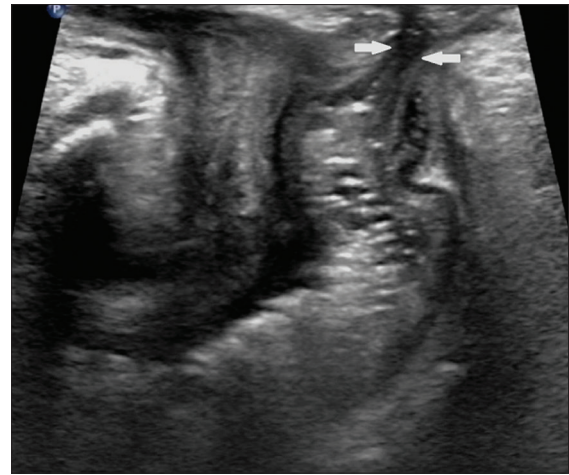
Sonographic manifestations of anorectal malformation. (a) Ultrasound (US) appearance of anorectal malformation seen by the transperineal approach in a 1-day-old male neonate. The rectum-perineum distance is 1.2 cm (asterisk shows the end of the rectum). (b) Transperineal US depicts the beak shape of the distal rectum in the same neonate. A recto-bulbar urethral fistula (arrows) communicated with the bulbar urethra (dashed line) is clearly depicted. (c) Cloaca seen by transperineal US in a 0-day-old female neonate. Midsagittal transperineal US shows a common channel (arrow) connected to the urethra (dashed line), vagina (triangles), and rectum (asterisks). (d) Contrast-enhanced colosonography identifies the bulbar rectourethral communication and the urethra (arrow)
